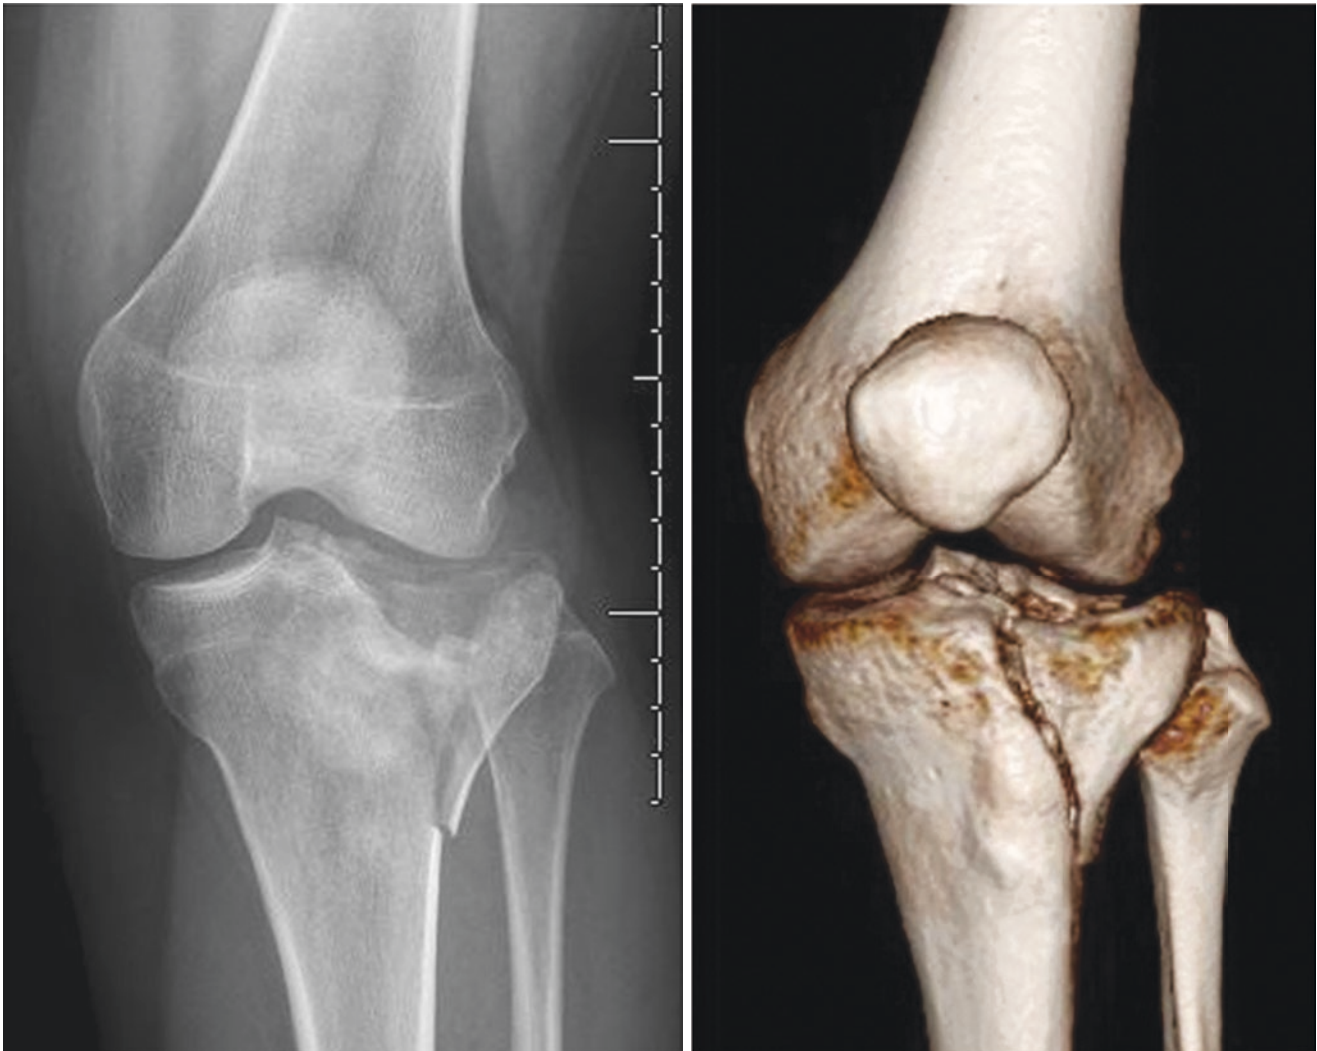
Anteroposterior radiograph of a displaced fracture of the lateral tibial plateau, accompanied by a 3D CT reconstruction image
